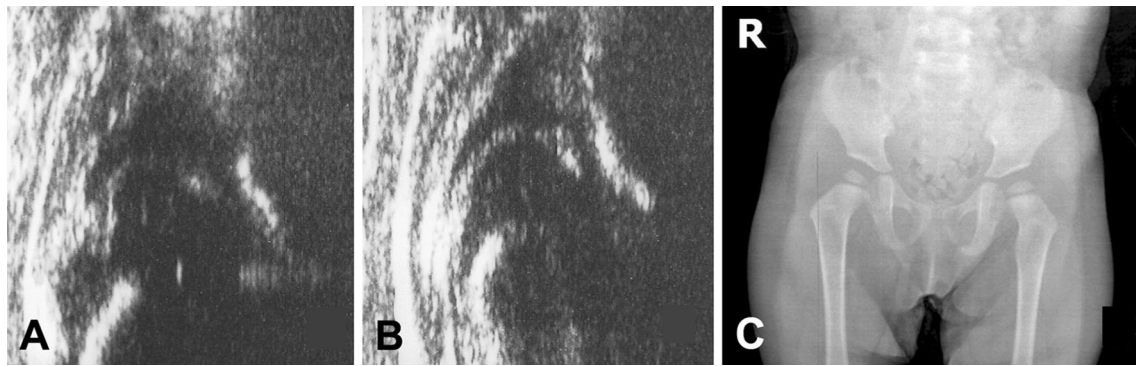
Right (A) and left (B) hip sonograms of a 110-day-old first-born girl with a history of breech presentation at the third trimester are seen. α angle was measured as 25° on the right side and 30° on the left side and the cartilaginous roof was pressed downward on both sides. Both hips were considered Graf Type IV. Graf Type I hip was achieved after 149-day-long Pavlik harness treatment in both hips. Radiographic examination at 26 months of age (C) revealed an acceptable short-term outcome in both hips.
